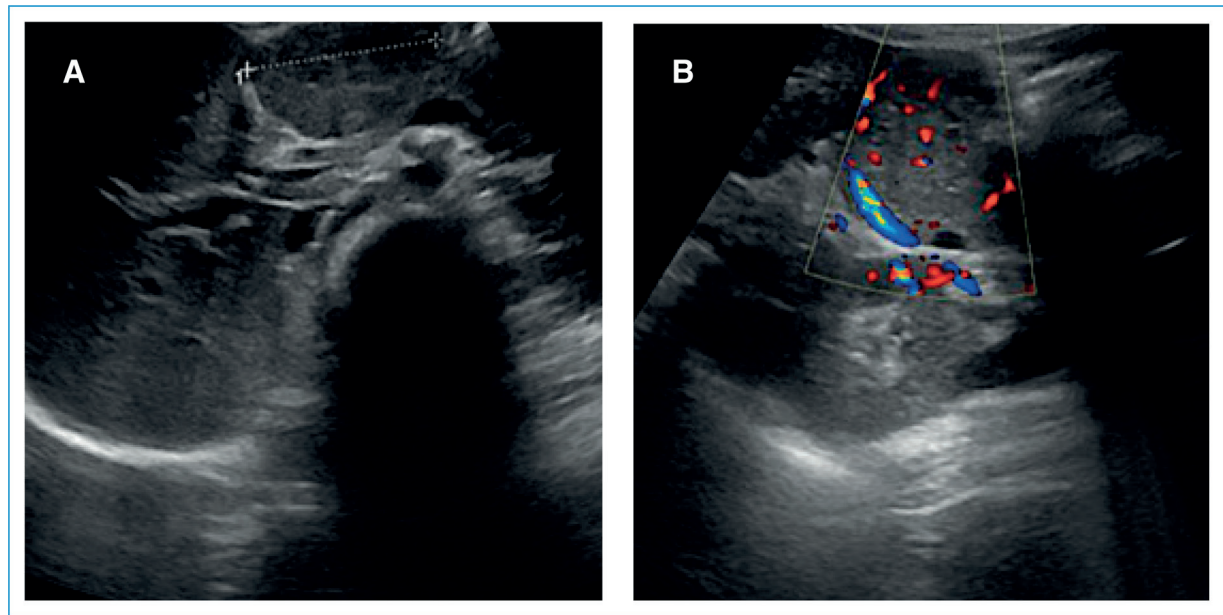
Liver ultrasound showing a solid well-defined isoechoic nodule in the left hepatic lobe (A), measuring 52 mm in diameter, with hypervascularity on color Doppler (B).
